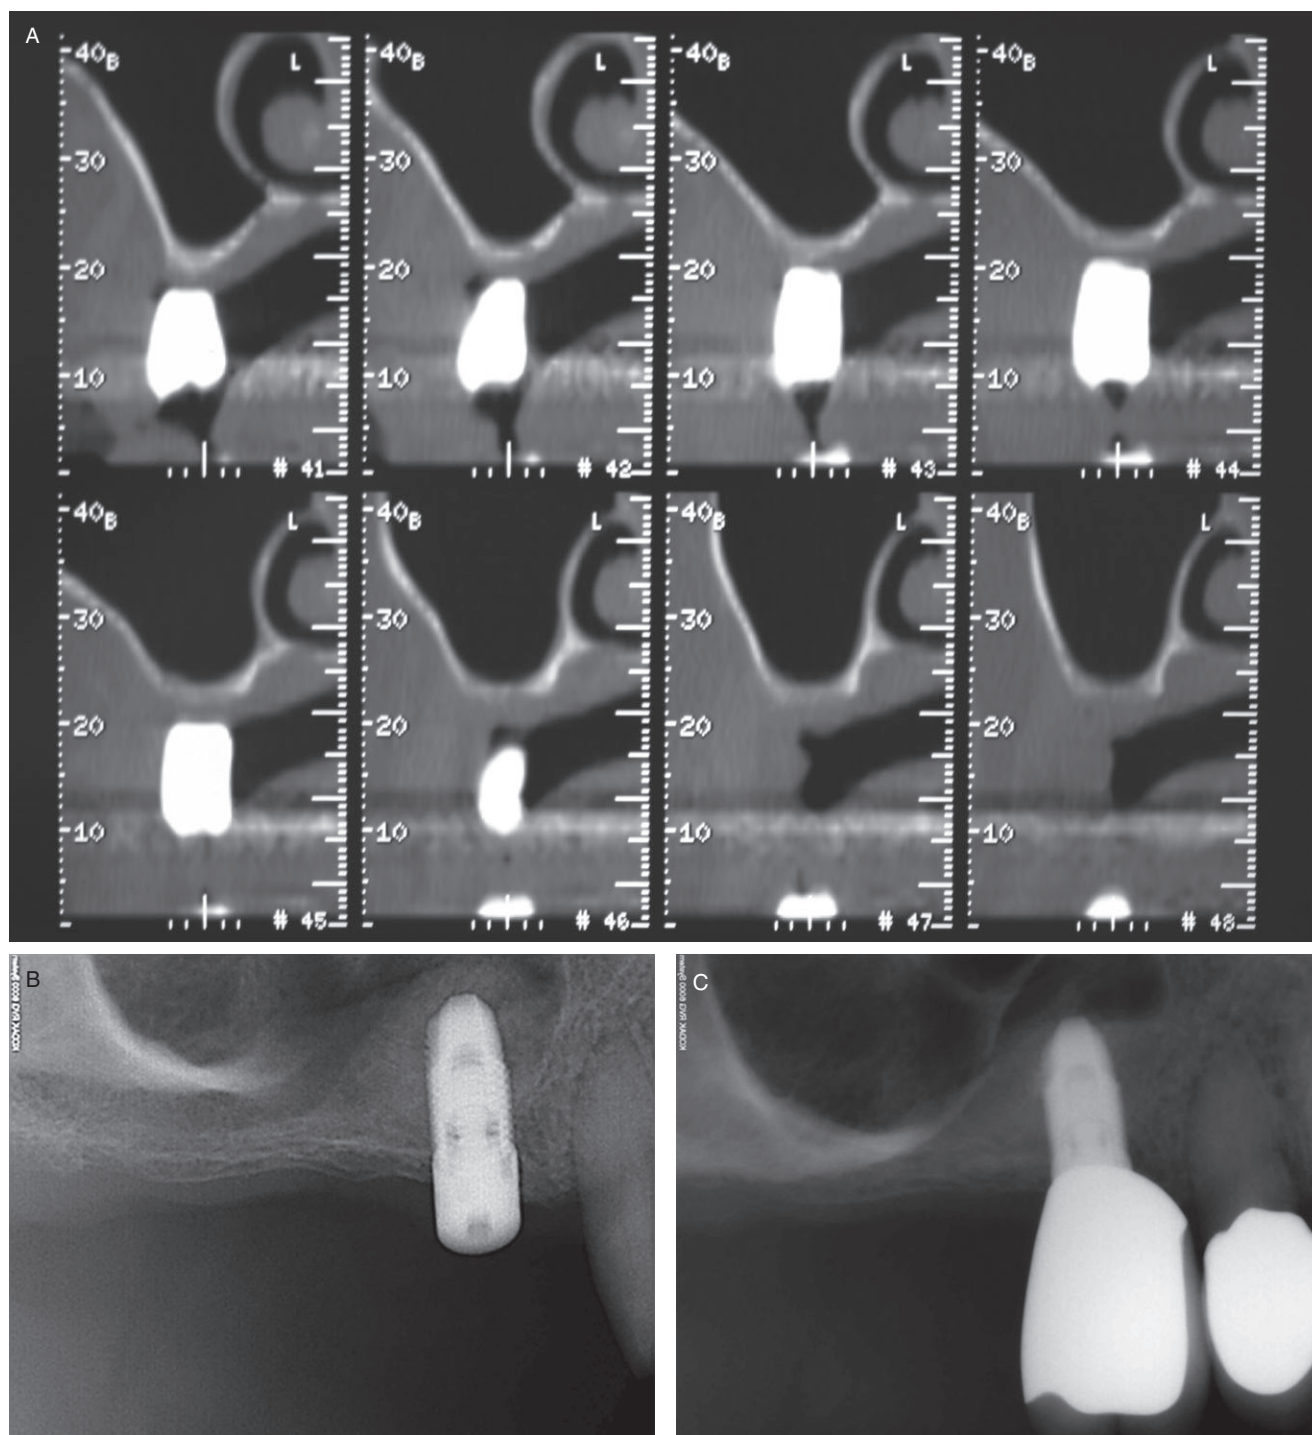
A, Computerized tomography scan measuring <2 mm of residual alveolar ridge height at the site of future implant placement. B, Periapical radiograph taken at the time of crestal approach sinus lift using intraoral bone as the graft material and simultaneous implant placement. C, Periapical radiograph taken at the time of crown installation, 8 months postsinus grafting and simultaneous implant placement.
